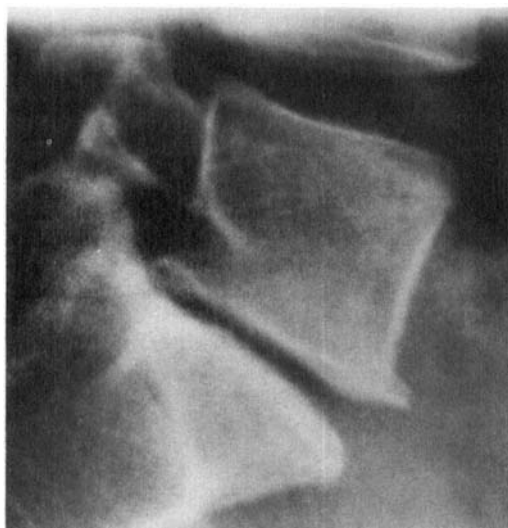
X-ray showing severe narrowing of the 5th lumbar disc with exostoses and sclerosing of the end plates in a woman of 50.
